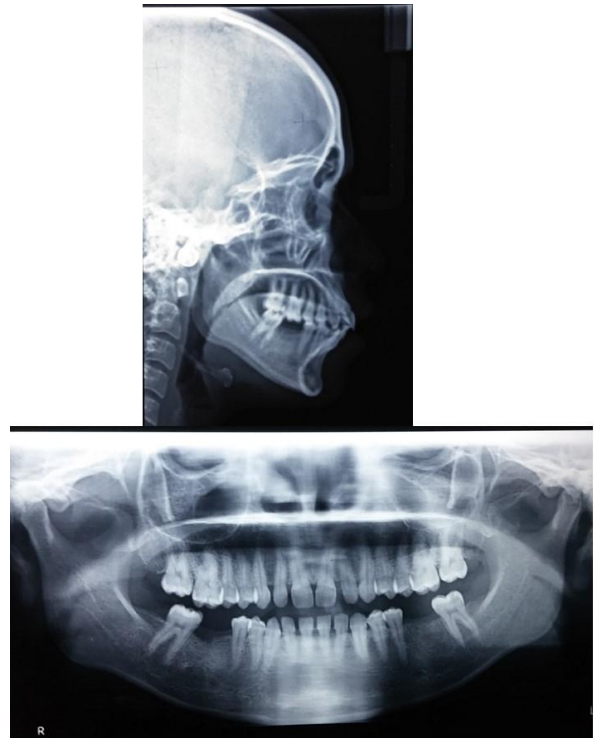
Pre-treatment lateral ceph and orthopantomogram.
